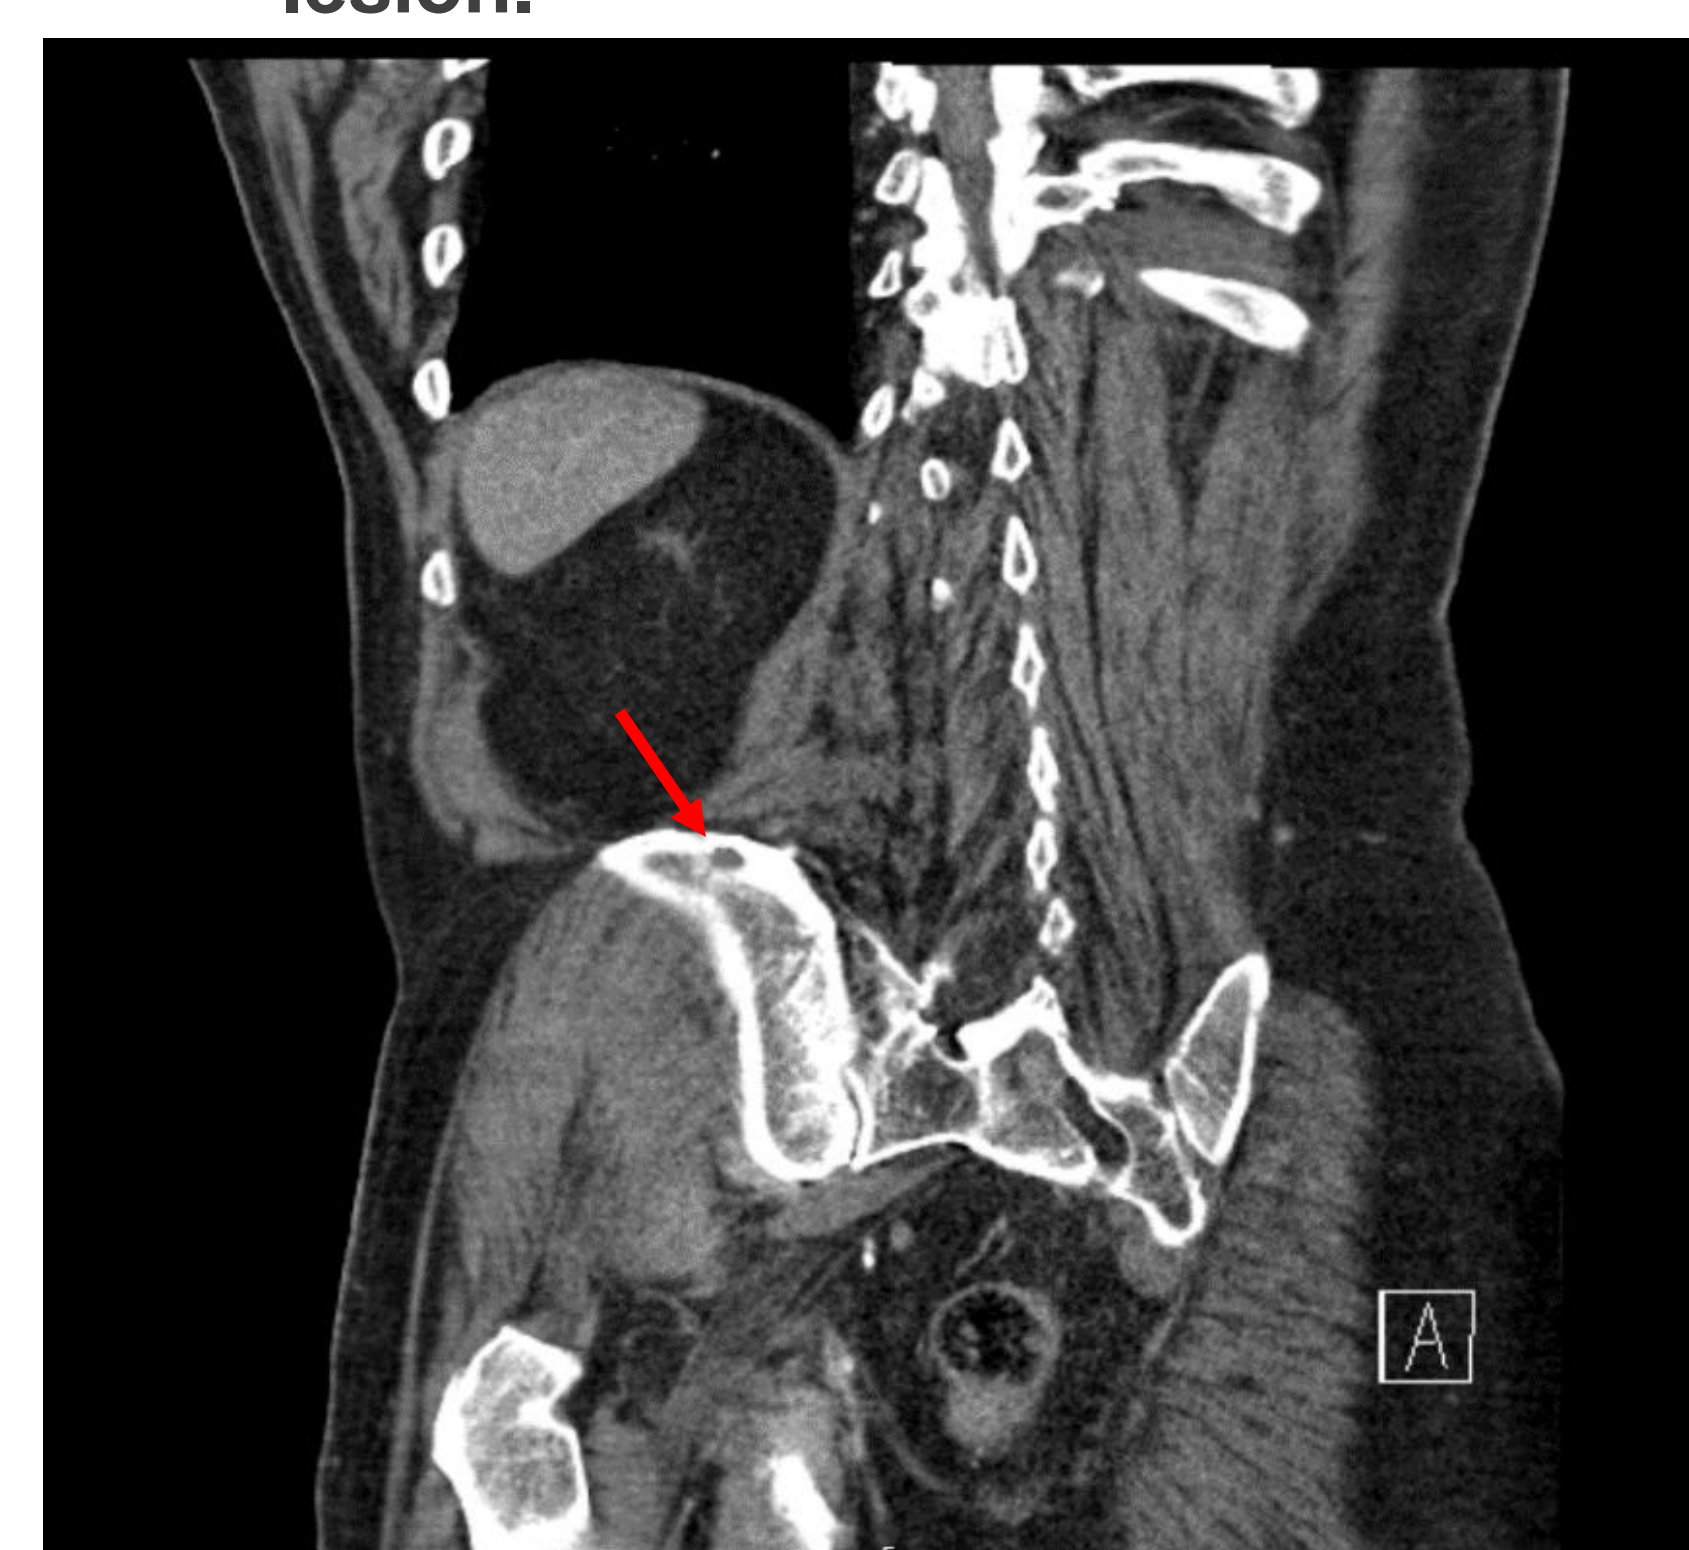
CT coronal showing lytic lesion in the right iliac bone posteriorly.
